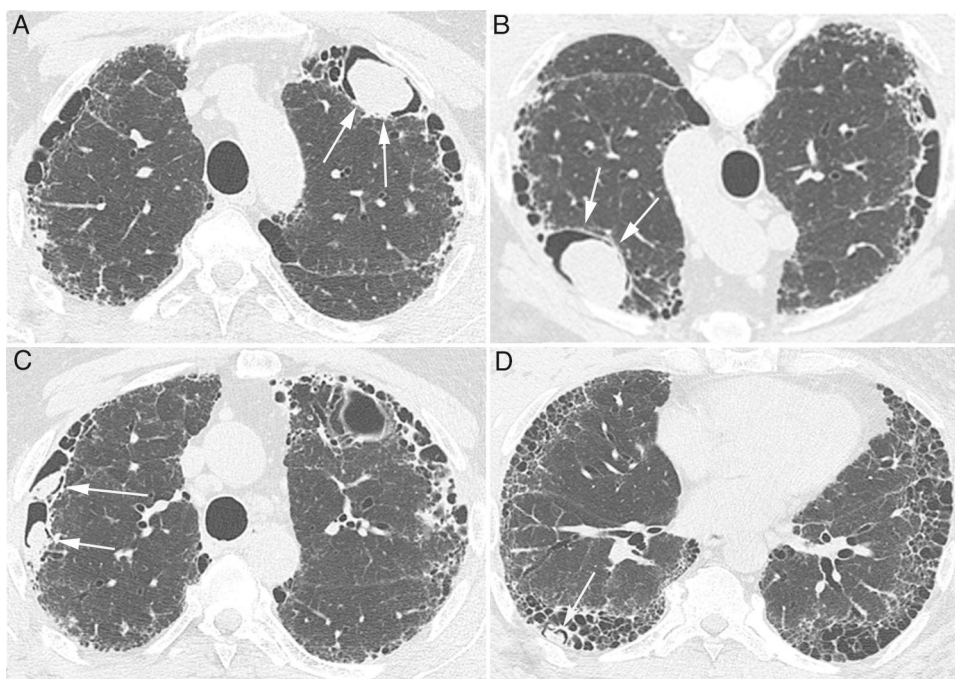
Chest CT images showing peripheral cysts pattern with honeycomb at the lung bases with an intracavitary nodule positioned anteriorly in the upper left lobe (A) that shifts position when the patient's decubitus is changed (B) (arrows). In C and D, small intracavitary nodules are visible inside cysts in the right lung (arrows).
